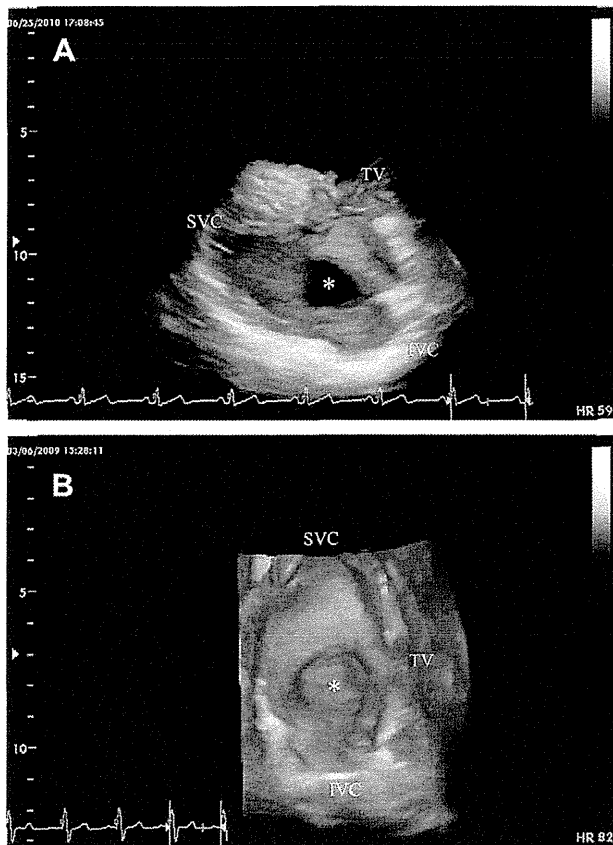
Three-dimensional transthoracic echocardiography of various shapes of the secundum-type ASD (*asterisk*) viewed from the right atrium. (A) Superoanterior rim deficient from the left parasternal approach, (B) inferoposterior rim deficient from the right parasternal approach. IVC, Inferior vena cava; SVC, superior vena cava; TV, tricuspid valve.
